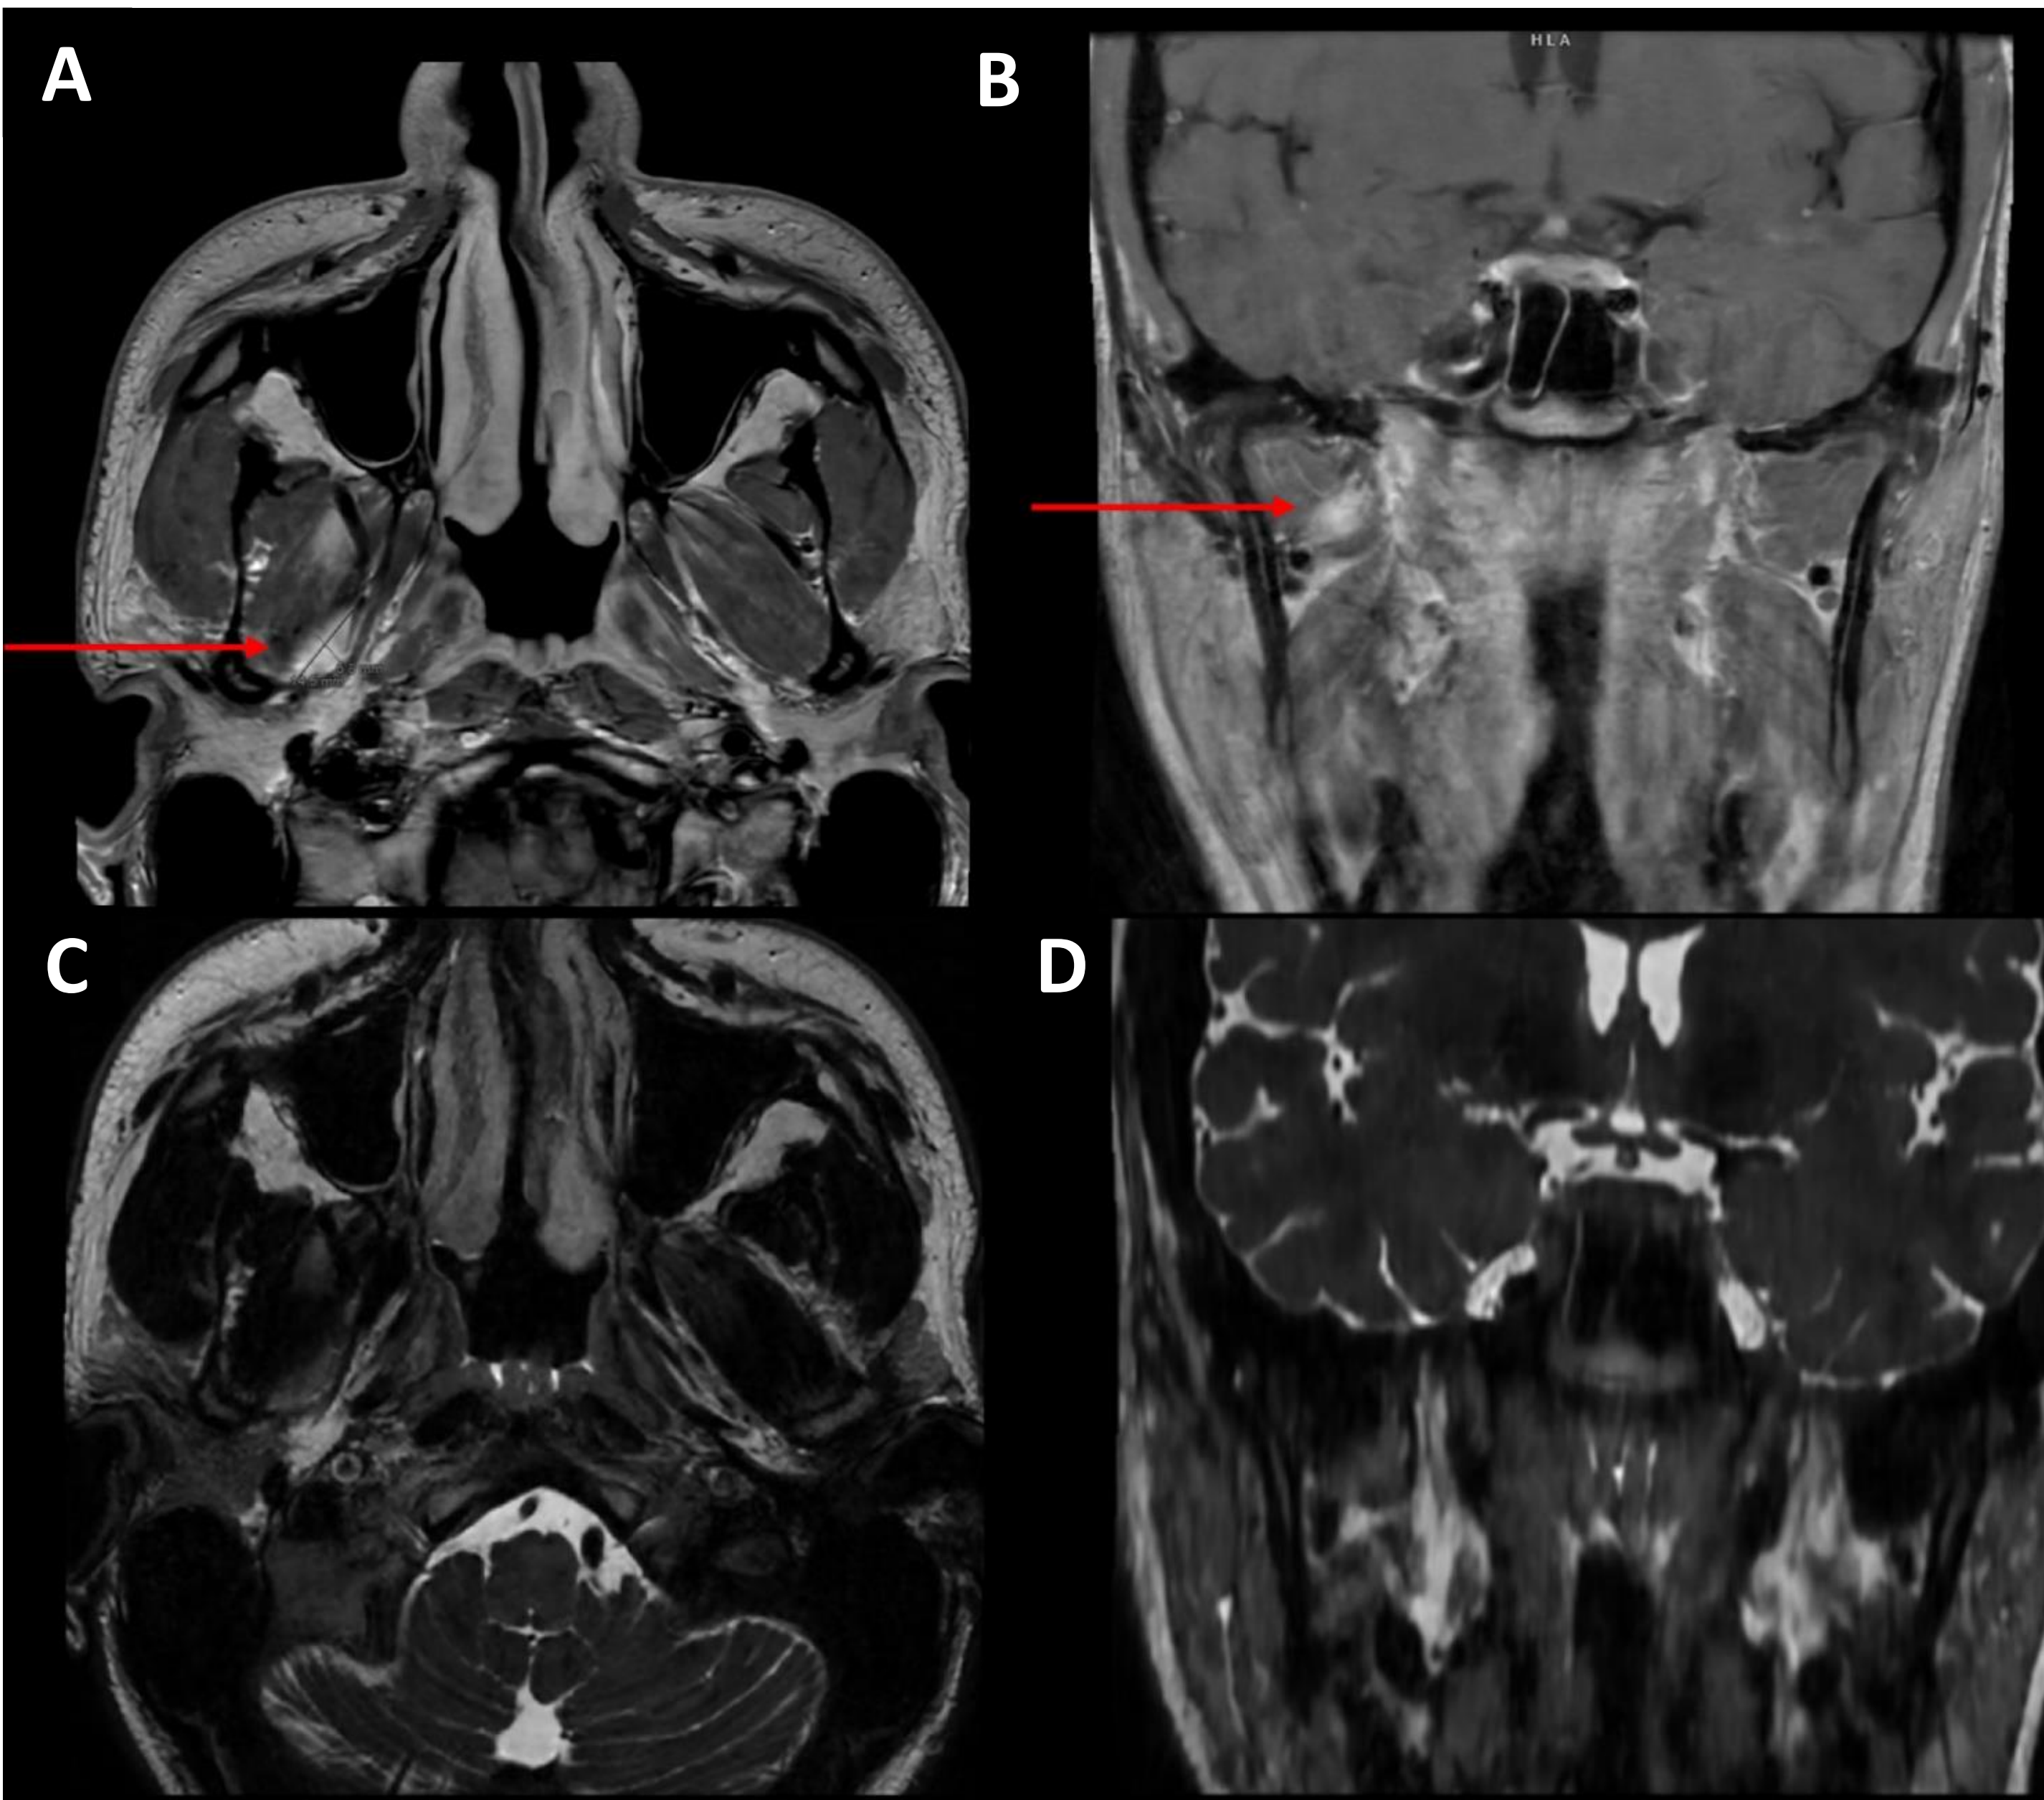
Pre-operative MRI demonstrating a 1.5cm enhancing lesion in the right masticator space (red arrow). No mass lesion was found intra-operatively, but the internal maxillary artery was found to be compressing V3. a) axial T1+contrast, b) coronal T1+contrast, c) axial T2, d) coronal T2.
